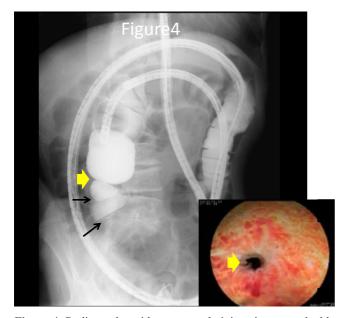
Radiography with contrast administration upon double balloon enteroscopy showed diaphragm-like strictures (arrows). Thick arrow indicates the pin-hole stricture that was observed by double balloon enteroscopy.
